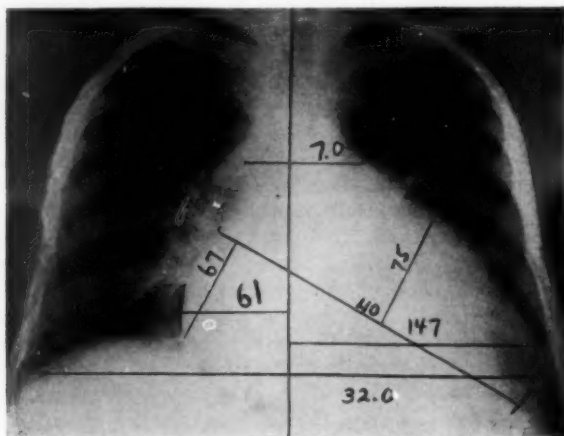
Roentgenogram of heart in case 2.
